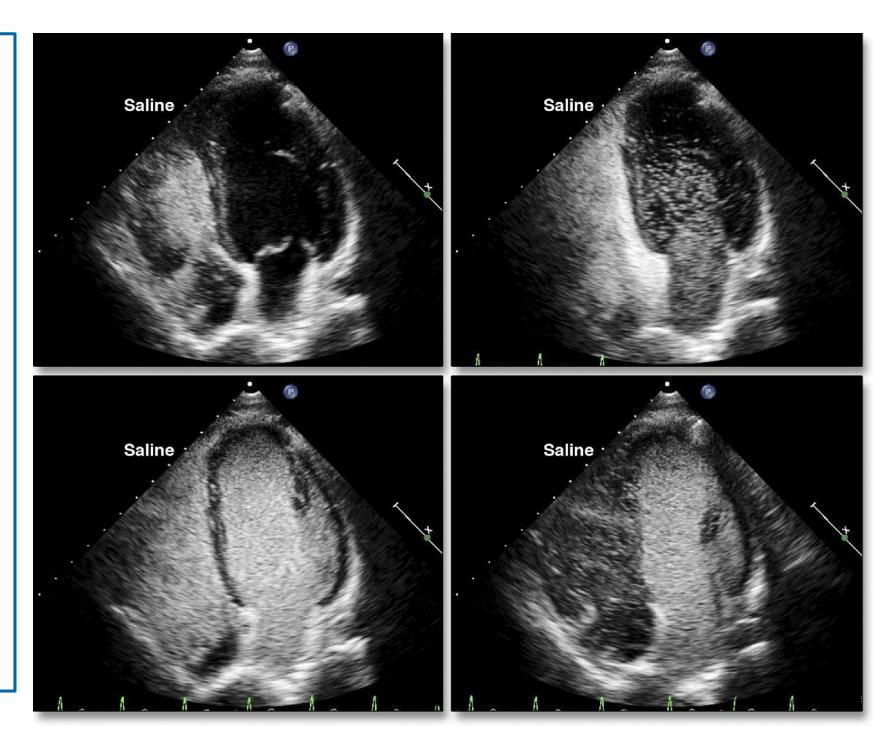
Saline microbubble transthoracic echocardiography (MTTE) in ESLD patient with severe HPS [5].
